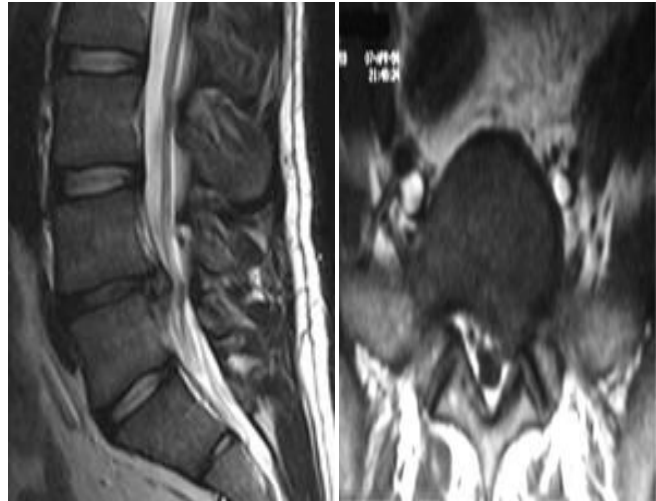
Pro-operative MRI of a patient showing L₄₋₅ prolapsed intervertebral disc sagittal / Para sagittal view and compression of left side nerve root axial view.
